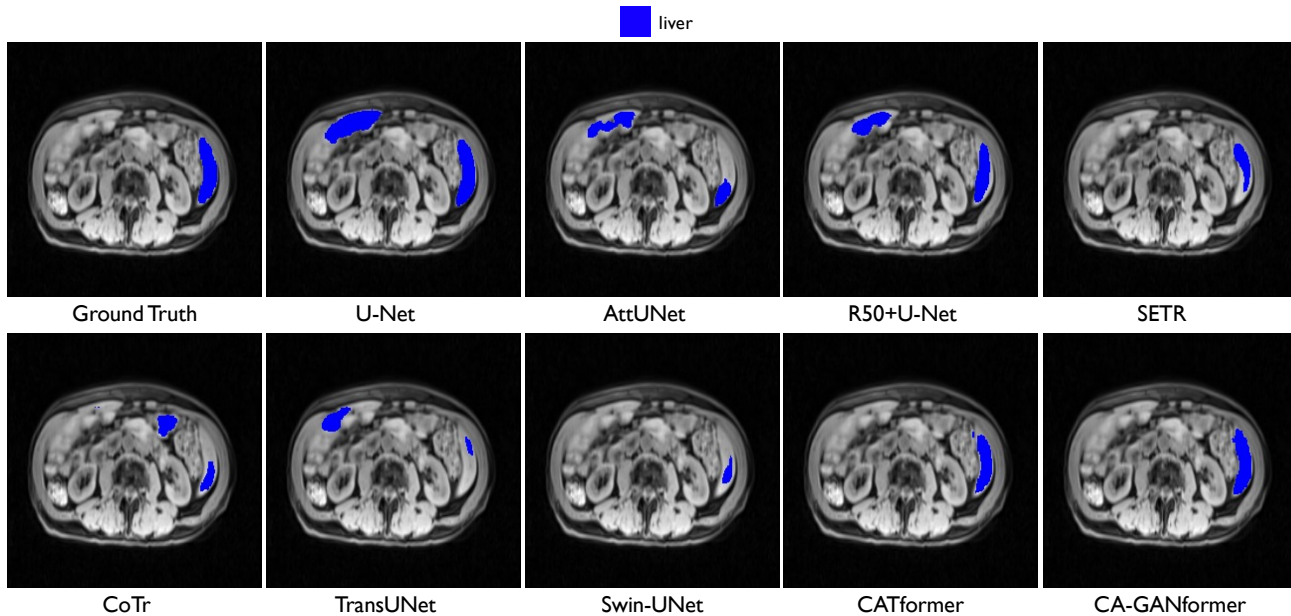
Visual comparisons with other methods on MP-MRI dataset.
